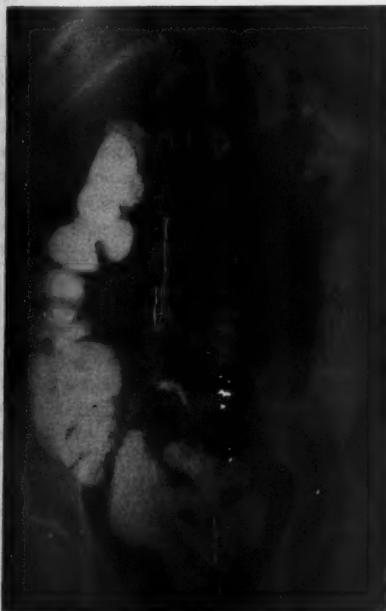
Barium enema x-ray from case 2 made 15 months after the primary resection.
